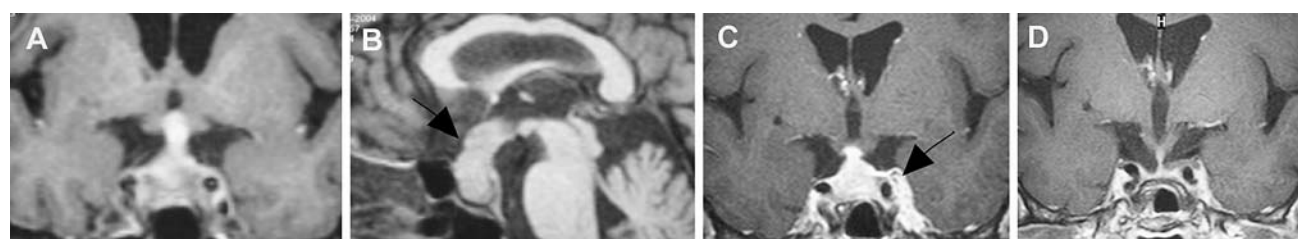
a Gadolinium-enhanced T1 MRI image showing a sellar mass with diffuse homogenous enhancement. b Pituitary stalk was diffusely thickened (arrow). c Ten months later, and without specific
